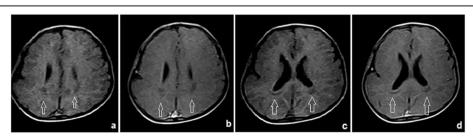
a–d MRI brain demonstrates ADEM ring enhancement pattern, axial post-contrast T1WI showing ring enhancement of bilateral parietal subcortical lesions (arrows)
